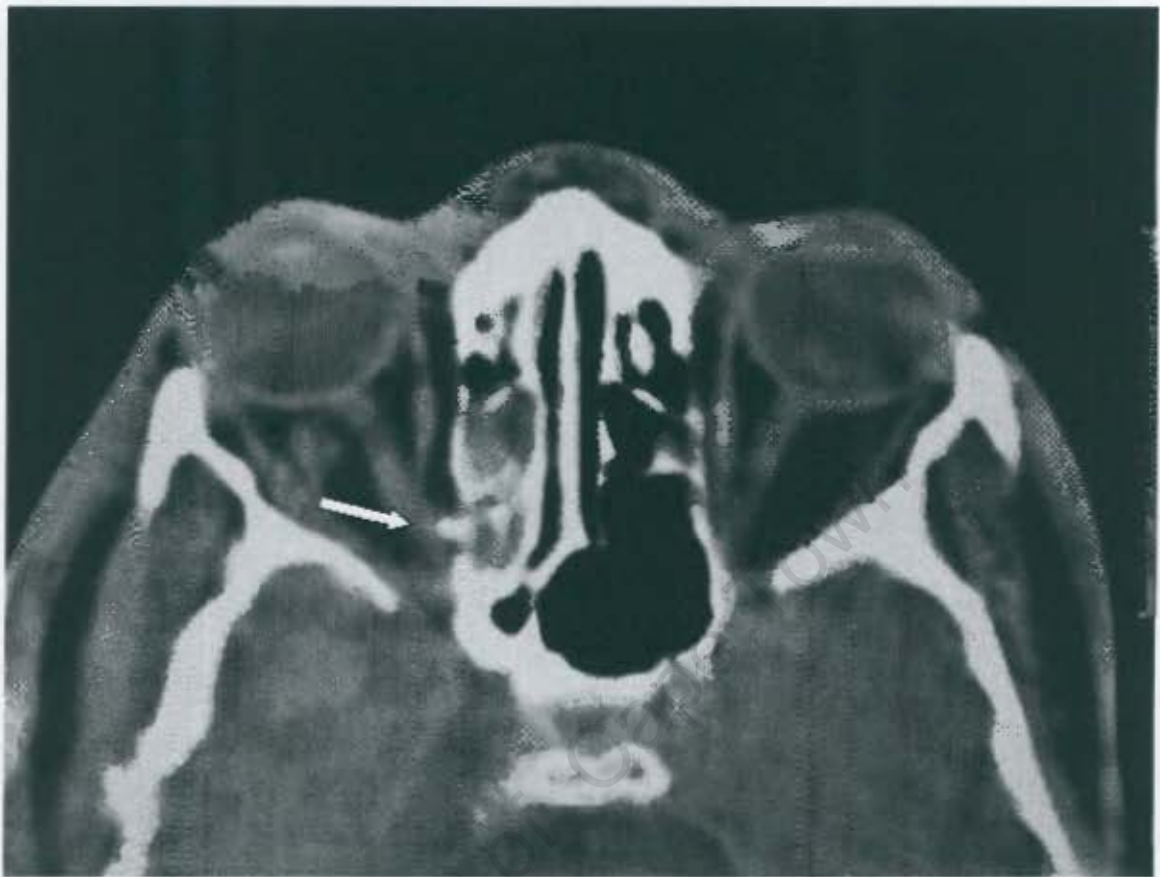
(D): Case 44. Axial CT of the orbits demonstrating the bone fragment (white arrow) impinging on the right optic nerve. The right globe was intact.
